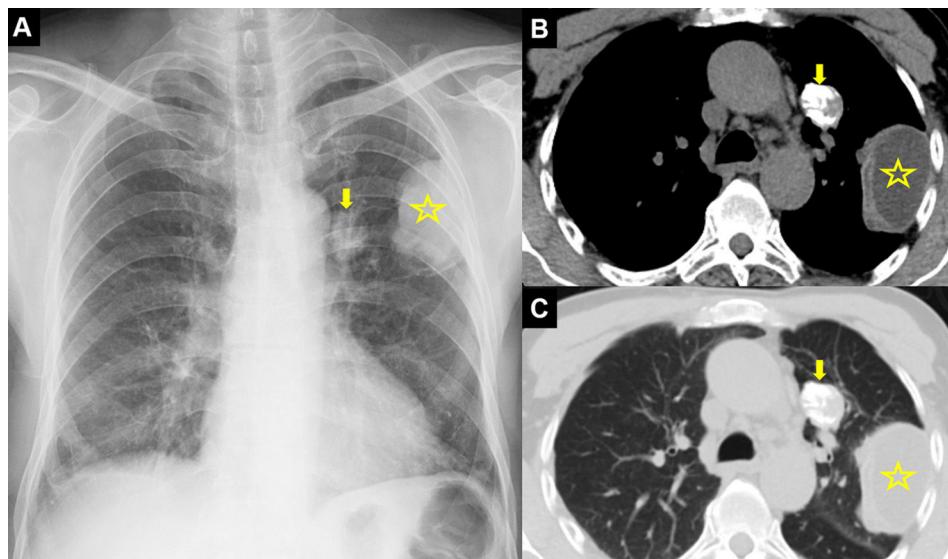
Posteroanterior (PA) chest radiograph (A) shows a perihilar calcified lesion (arrow) and a peripheral radiopaque lesion (star) with smooth margin in the left lung. Thoracic computed tomography mediastinal (B) and parenchymal window axial sections (C) show a 30 mm × 24 mm lesion with diffuse calcification in the anterior segment of the upper lobe of the left lung (arrow) and a 60 mm × 40 mm cystic lesion in the upper lobe apicoposterior segment (asterisk) in the pleural neighborhood.
